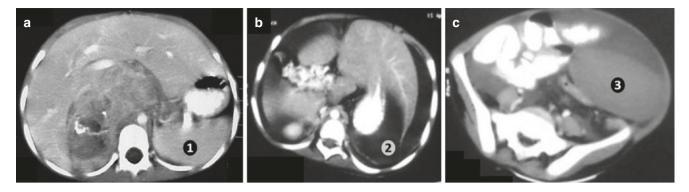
CT with oral and IV contrast is useful in diagnosing wandering spleen. (a) Normal CT showing spleen (1) in its normal position. (b and c) Show CT imaging of a patient with wandering spleen. The
